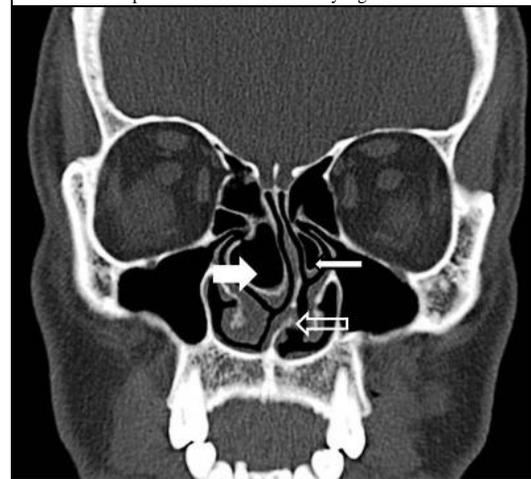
Coronal CT of paranasal sinuses shows the deviated nasal septum (White outlined arrow) and bilateral concha bullosa (white arrows).
